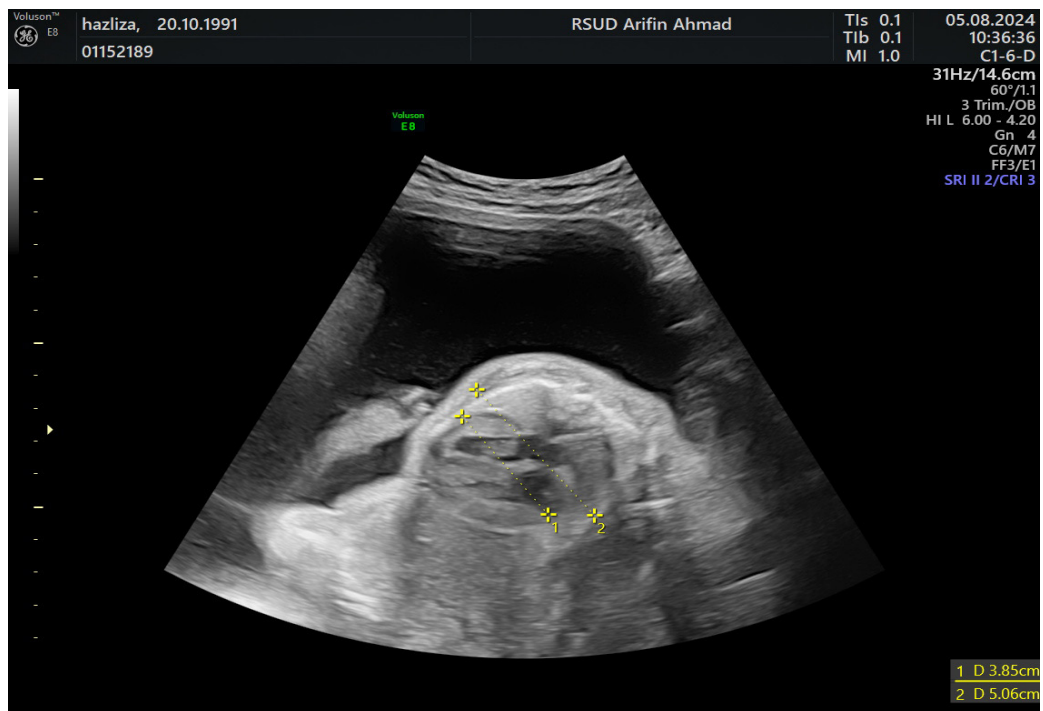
The second fetal ultrasound showed cardiomegaly with CTR >50%
